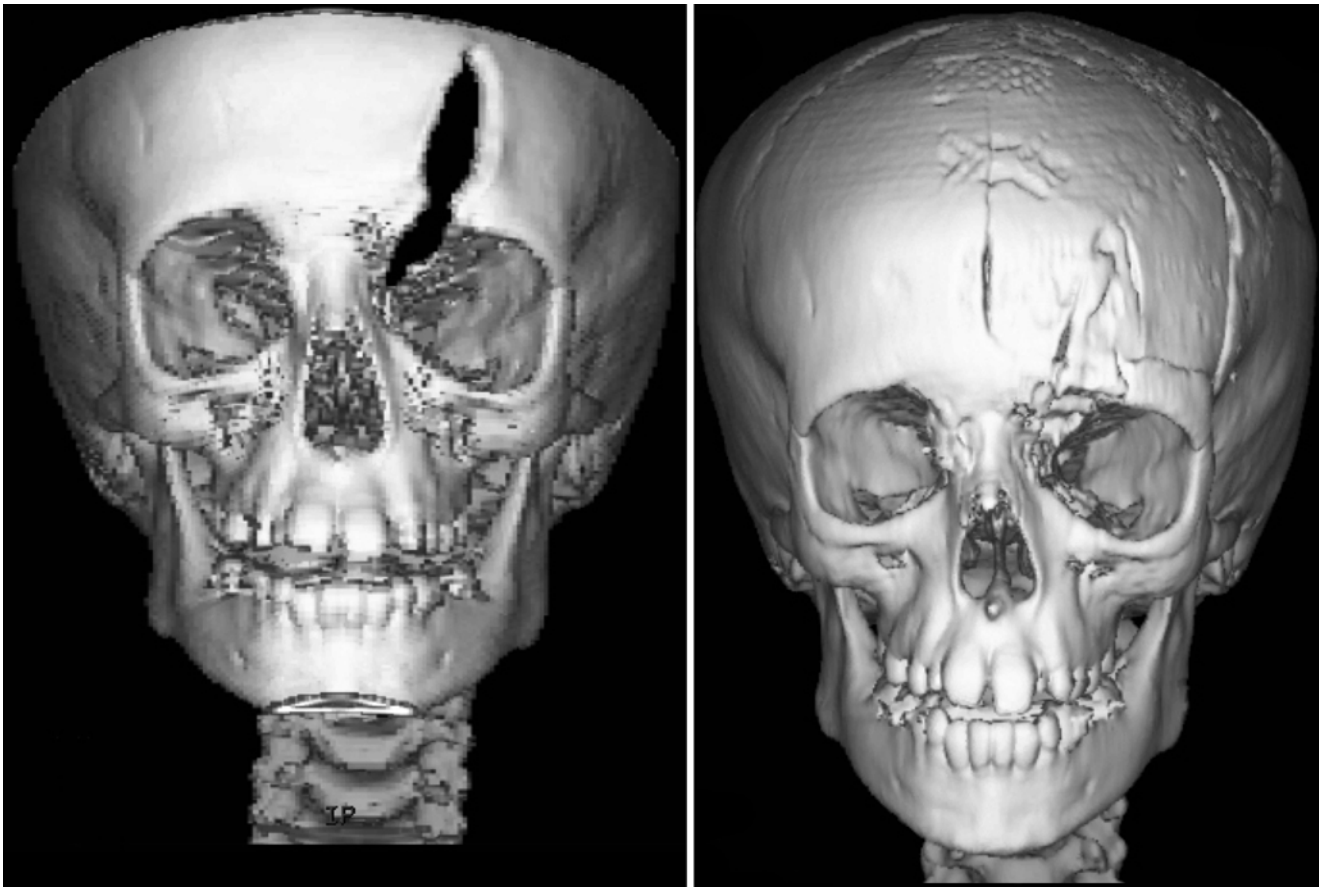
3D CT demonstrating the growing skull fracture pictured in Figs. 23.9, 23.10, and 23.11 before (*left*) and after (*right*) reconstruction
